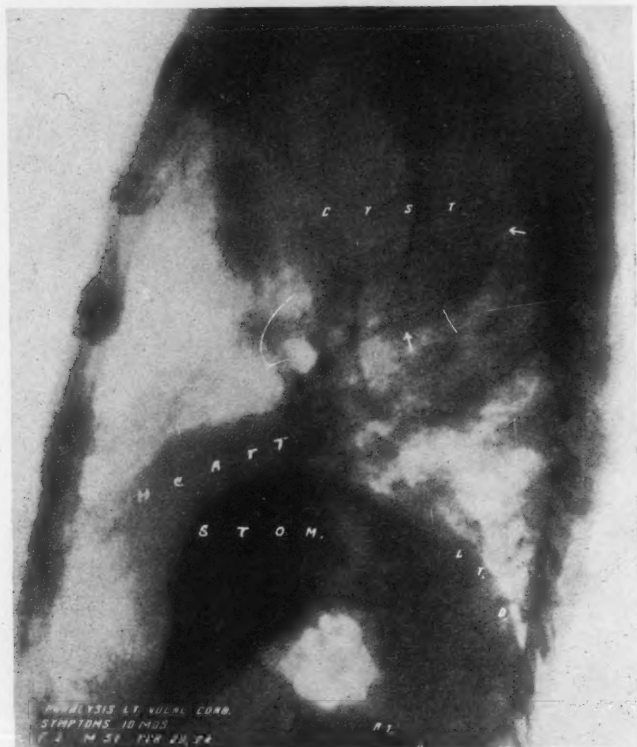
Lateral projection of mediastinal cyst. Note central location. Also note eventration of diaphragm with stomach in contact with the high left side of diaphragm. (Radiograph by Dr. L. T. LeWald.)
